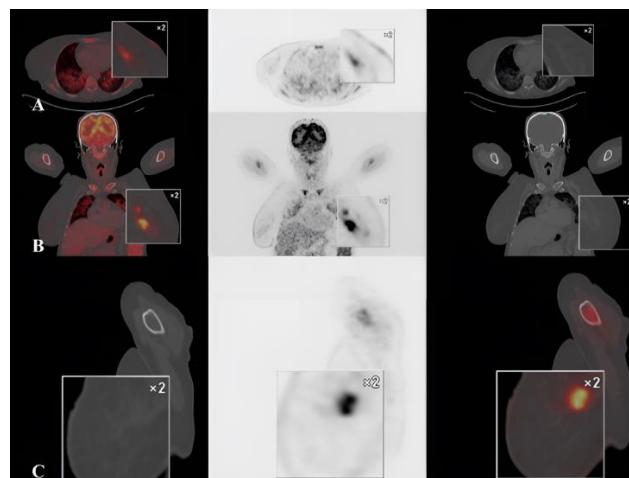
Positron emission tomography–computed tomography (PET / CT) sections of patient: A. Axial (transverse), B. Coronal, C. Sagittal planes
